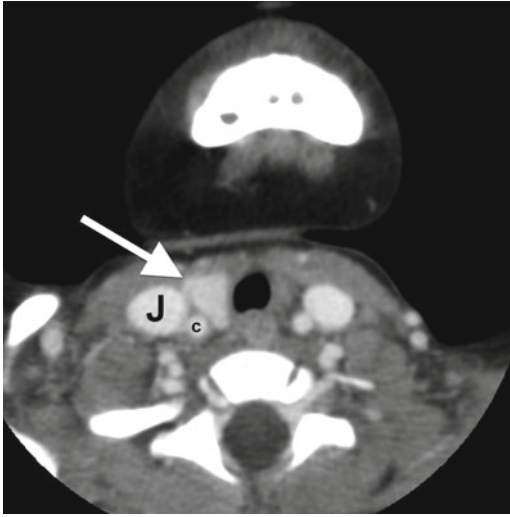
Left thyroid hemiagenesis. Axial CT image in a 26-month-old with a retropharyngeal abscess shows absence of the left lobe of the thyroid gland. The right lobe is shown with an arrow, and the right jugular vein (*J*) and carotid artery (*c*) are also annotated. Although not present in this child, patients with an absent left thyroid lobe usually have a small, but blunted isthmus.
